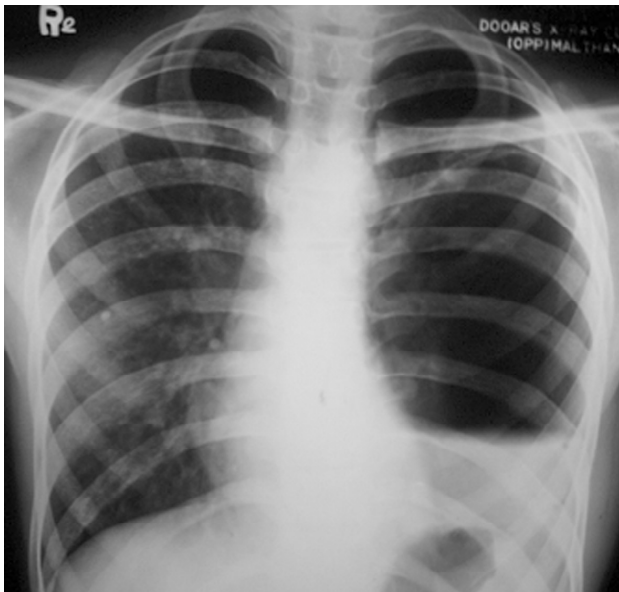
Chest X-ray was misinterpreted as left-sided pyopneumothorax with horizontal air-fluid level. The left costophrenic angle appeared to be obliterated.
